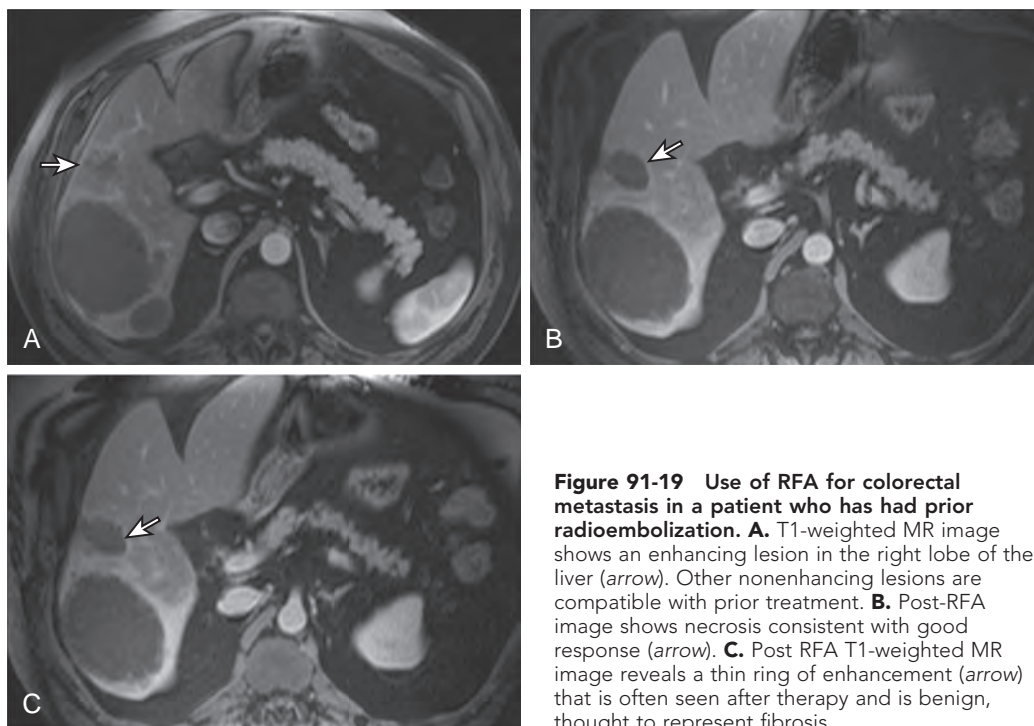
Use of RFA for colorectal metastasis in a patient who has had prior radioembolization. A. T1-weighted MR image shows an enhancing lesion in the right lobe of the liver (arrow). Other nonenhancing lesions are compatible with prior treatment. B. Post-RFA image shows necrosis consistent with good response (arrow). C. Post RFA T1-weighted MR image reveals a thin ring of enhancement (arrow) that is often seen after therapy and is benign, thought to represent fibrosis.
